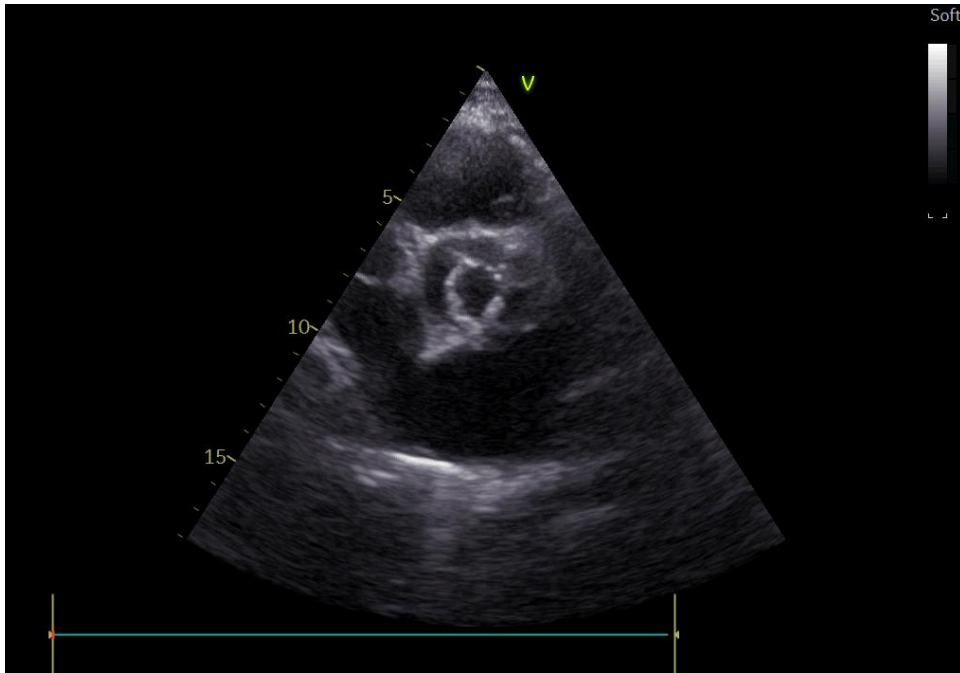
Transthoracic echocardiography showing the bicuspid aortic valve.
